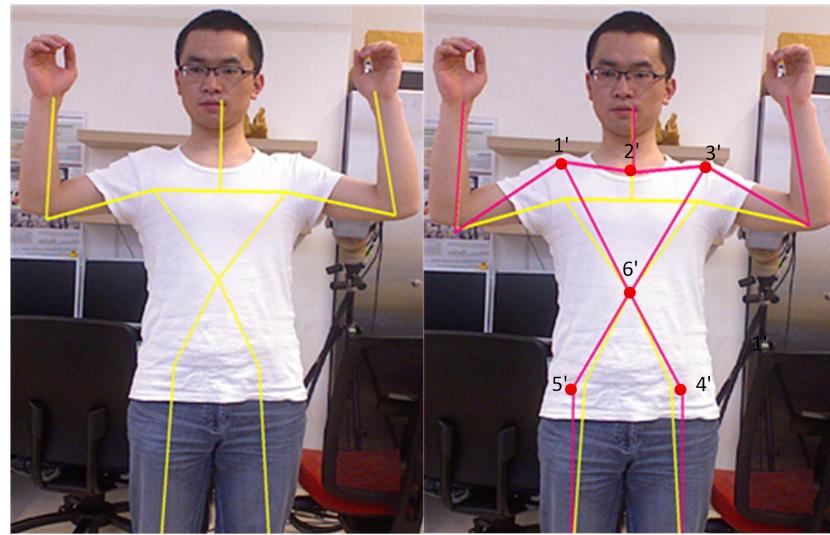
Selected anatomical points for Kinect skeleton improvement and subsequent CT warping and interpolation.
